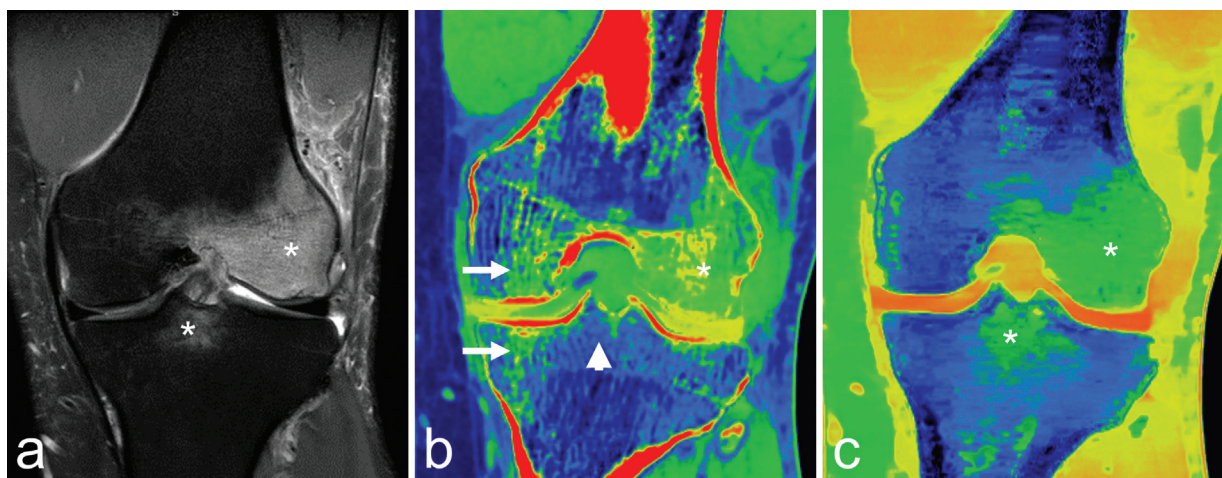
A 46-year-old man with left knee pain. (a) Coronal intermediate-weighted fat-suppressed image shows edema-like signal intensity of the lateral femoral condyle and the tibial eminence (asterisks). Two types of coronal color-coded dual-energy computed tomography reconstructions are displayed: (b) virtual non-calcium and (c) virtual non-hydroxyapatite, showing the influence of postprocessing. There are false positives (arrows) and false negatives (arrowhead) (b).
